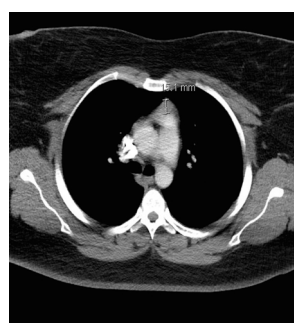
CT thorax showing abnormal mediastinal mass consistent with thymic hyperplasia.
